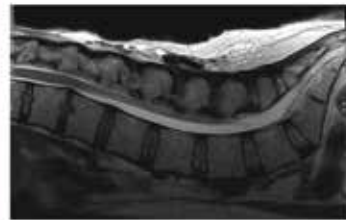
Cross-sectional MRI scan. The catheter is visible in the epidural space, and the surrounding tissue appears normal.
